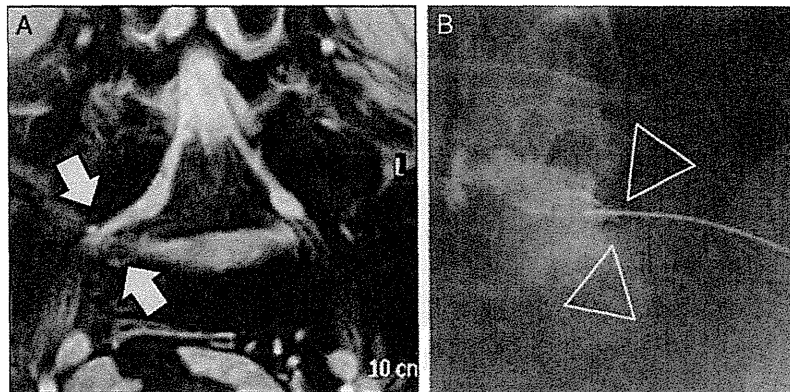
An example of 3-dimensional imaging study and selective radiculography of fifth lumbar spinal nerve in case of extraforaminal stenosis at the lumbosacral junction. A, On the multiplanar reformat view obtained from 3-dimensional-magnetic resonance imaging studies, extraforaminal entrapment of the fifth lumbar spinal nerve between the bony spur and the sacral ala is clearly demonstrated (white arrows). The swelling of the nerve and spinal ganglion is also well depicted. B, Selective radiculography of the fifth lumbar spinal nerve shows complete block in the extraforaminal zone (open white triangles), which usually occurs between the sacral ala and osteophyte projecting laterally off the inferior endplate of the L5 vertebra.
